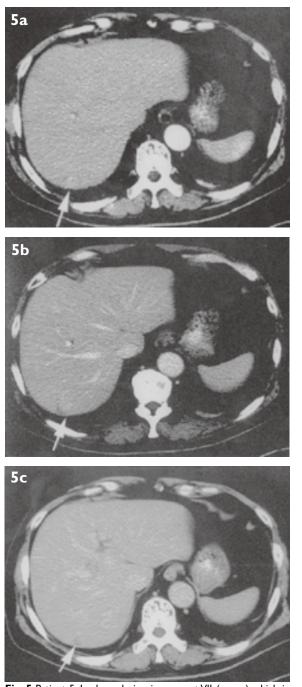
Patient 5. Isodense lesion in segment VII (arrow) which is hardly discernible on the (a) enhanced arterial phase CT image, fading off with a pseudo-capsule on the (b) portal venous phase CT image, and becoming hypodense during the (c) delayed phase (detected readily). A pre-contrast CT image will help to better characterise the lesion (arterial enhancement is observed when the lesion changes from hypodense (pre-contrast) to isodense (arterial phase) relative to surrounding parenchyma).
